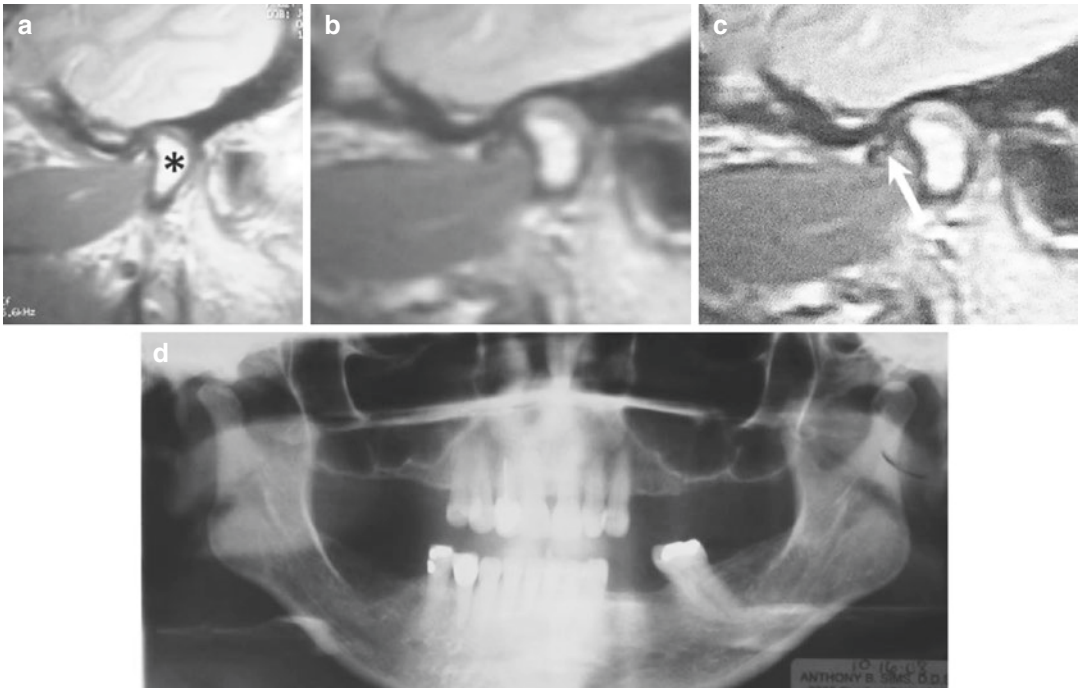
Chronic obstructive pulmonary disease (COPD) patient (Case 10). The MRIs (a–c) and panoramic X-rays (d) of the Case 10 patient show bilateral anterior displacement of the menisci (dark sinusoidal tissue marked with white arrow in panel c) of the temporomandibular joints, as well as distal displacement and erosion of the condyles (condylar head in A marked with an asterisk). Image quality in Panel c has been enhanced using unmask sharp image processing. The dark line between the condylar head and the convolutions of the brain is the temporal bone
